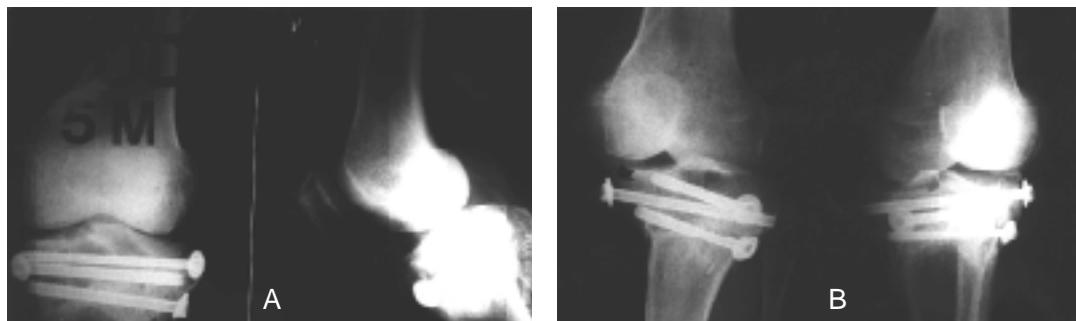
Postop. 5 months radiograph of total condyle type of the fracture ; it shows loss of fixation of one cannulated screw and washer.
